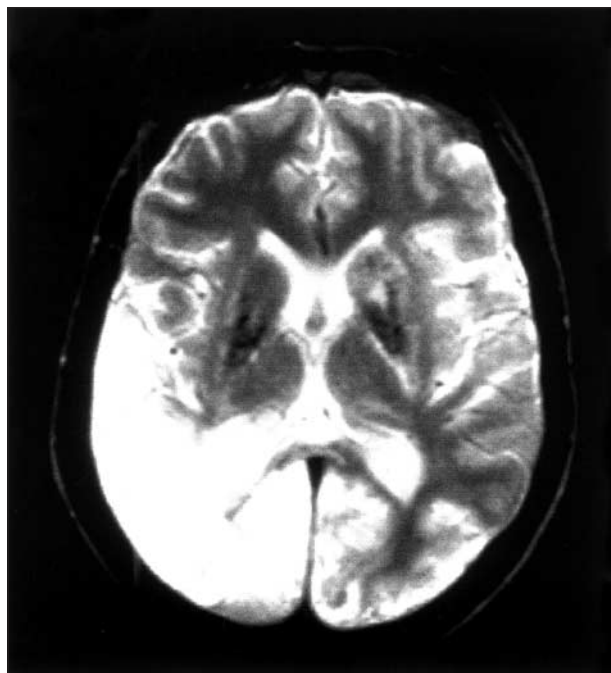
Axial noncontrast T2-weighted magnetic resonance image in the proband (III:1).
